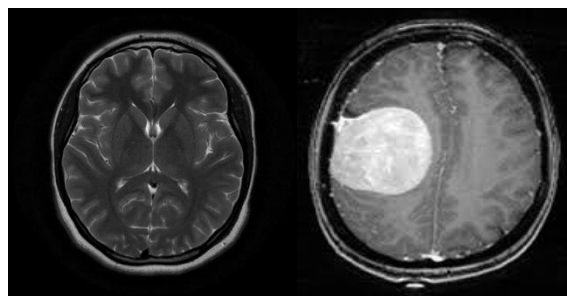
Brian MRI Images Normal Vs. Tumor
